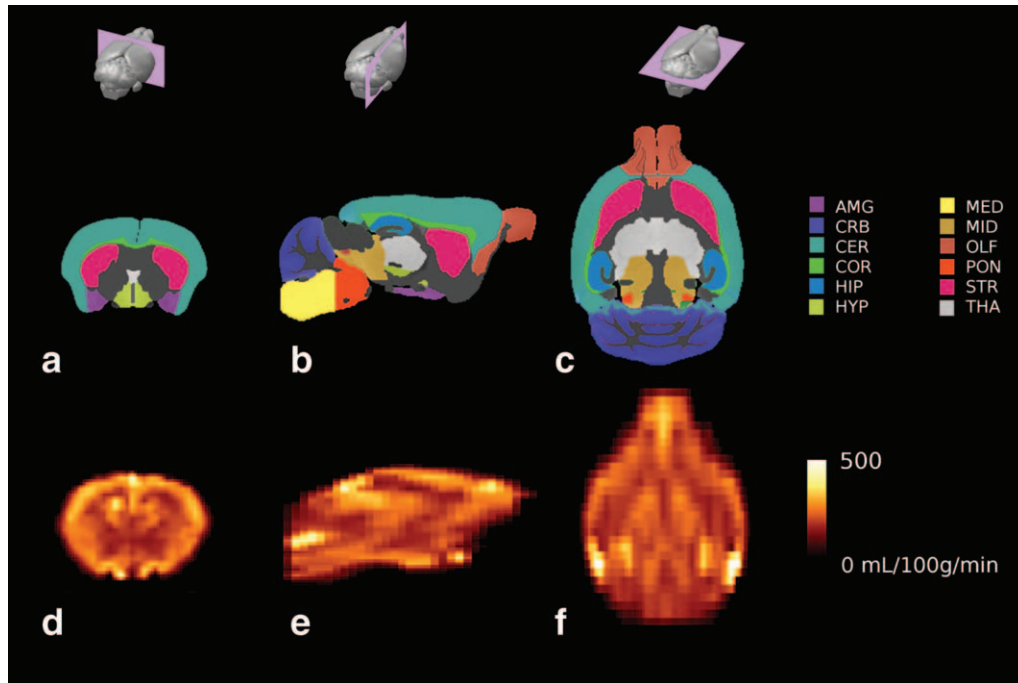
Regions of interest in MRI atlas (top row) for coronal (a), sagittal (b), and transverse (c) images with corresponding mean CBF map (d, e, and f, respectively). In this figure, CBF images were interpolated by a factor of two. Legend: AMG, amygdala; CRB, cerebellar cortex; CER, cerebral cortex; COR, corpus callosum; HIP, hippocampus; HYP, hypothalamus; MED, medulla oblongata; MID, mid-brain; OLF, olfactory bulbs; PON, pons; STR, striatum; and THA, thalamus.
